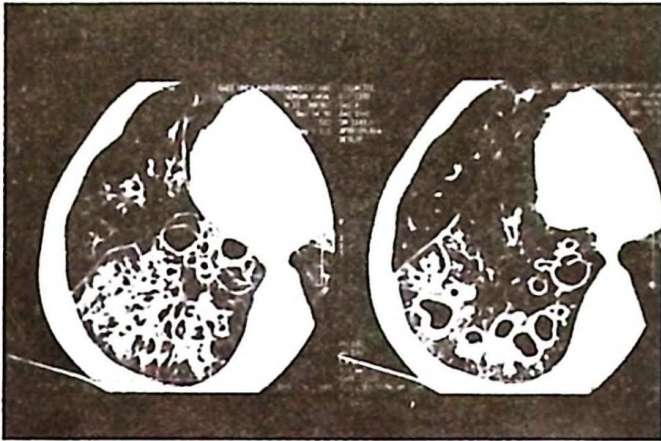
A thoracic high resolution CT scan shows multiple rounded lucencies with discrete walls representing severe cystic bronchiectasis with prominent bronchial wall thickening almost entirely replacing the right lower lobe.
